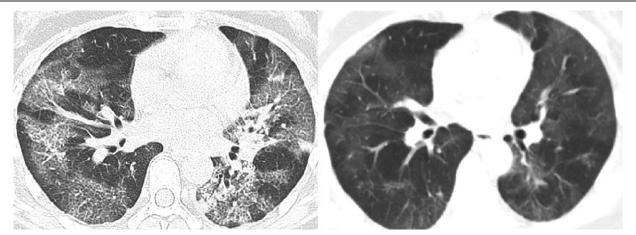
Chest CT images of patient 14 with COVID-19 caused by household exposure of her husband patient 9. (A) Chest CT images on day 6 after symptom onset showed the bilateral GGOs with mixed linear opacities. (B) Chest CT images showed the improvement in bilateral GGOs at 1-mo follow-up after discharge.
